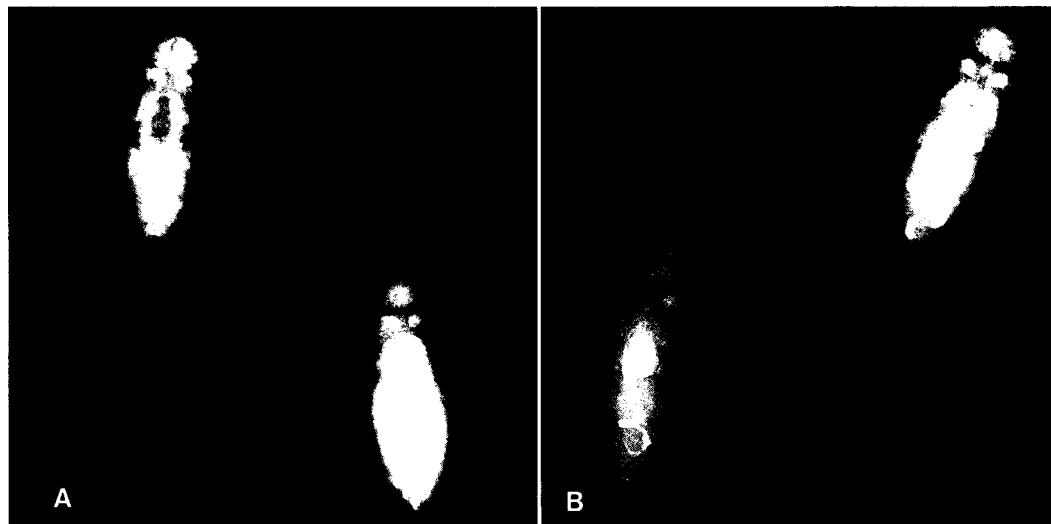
a. Radiograph of crickets fed 2% calcium diet for 72 hr. The gastrointestinal tract is poorly defined. b. Radiograph of crickets fed 12% calcium diet for 72 hr. The gastrointestinal tract is outlined as a radiopaque structure along the midline of the cricket. The radiopacity is presumably due to calcium contained in the gut.
